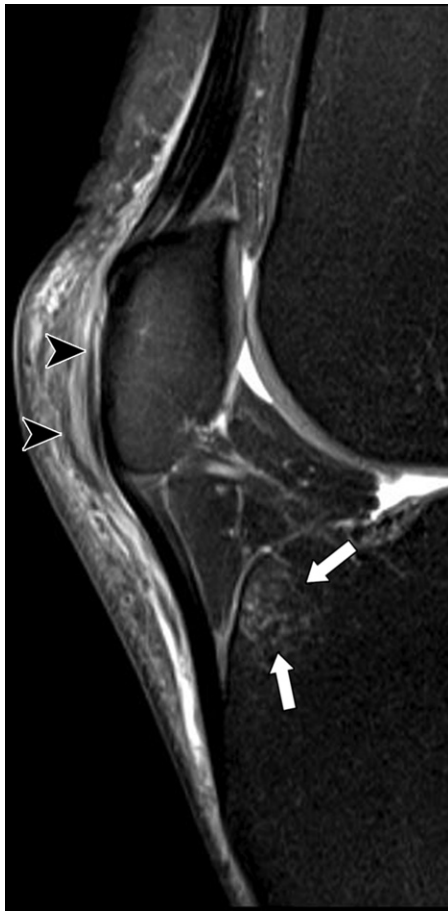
Superficial prepatellar bursitis after direct trauma in a 42-year-old man who sustained a dashboard injury. Sagittal T2-weighted fat-suppressed MR image shows fluid in the prepatellar soft tissues. A well-defined laminar fluid collection is present overlying the patella, with linear hypointense septa within it (arrowheads) representing the fibrous layers that demarcate the bursae. There is ill-defined edema in the subcutaneous tissues. Note the bone edema at the anterior tibia (arrows) related to bone contusion.
